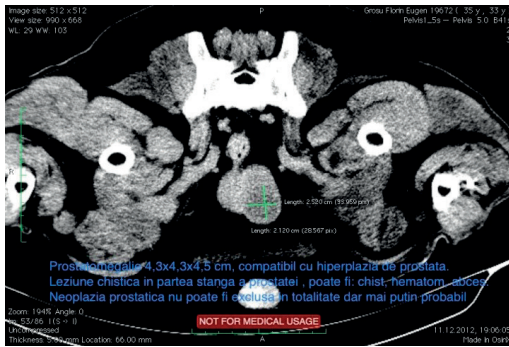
CT scan of patient with paraprostatic cyst (Dr Grosu Florin)
